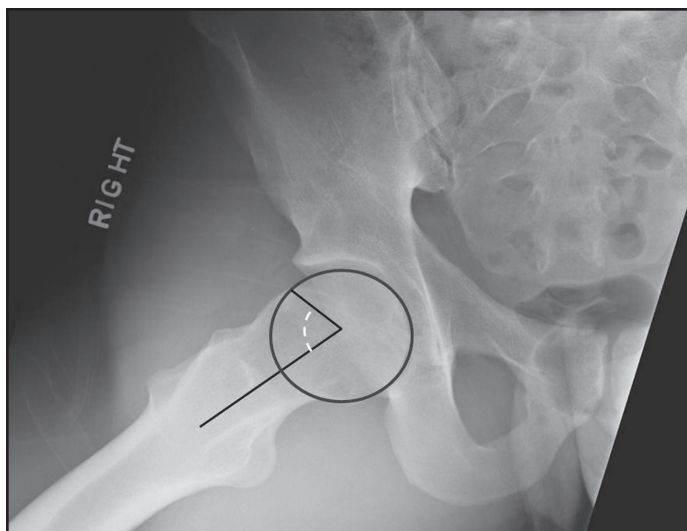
Dunn lateral radiograph demonstrating α angle.
